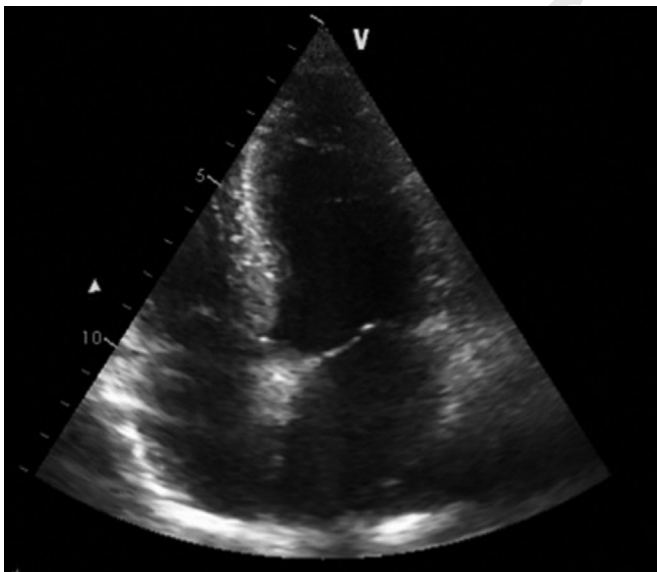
Echocardiography showed characteristic kinetic disturbances in the apical heart region.
